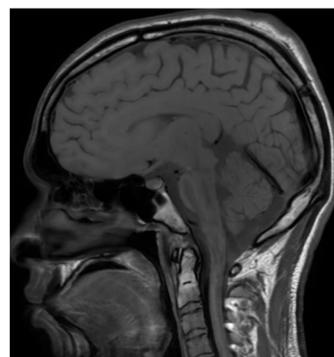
Post-operative MRI scan showing the gross total resection of the clival lesion.
